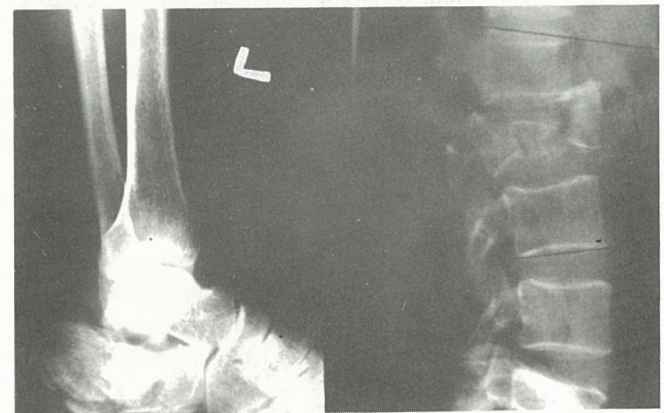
A : Radiographs of a patient (NYK) with a severely comminuted fracture Denis' Type E of the L2 vertebra and associated fracture calcaneum.
